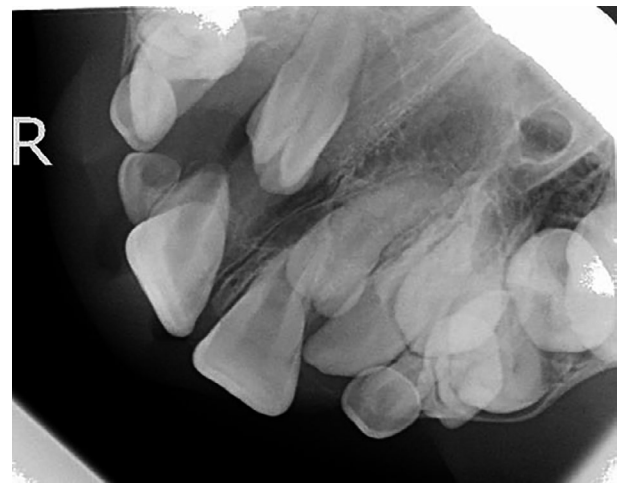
An upper standard occlusal radiograph revealed two unerupted tuberculate supernumerary teeth. There is a radiolucency associated with the right supernumerary tooth extending towards the developing right premolars and towards the midline
